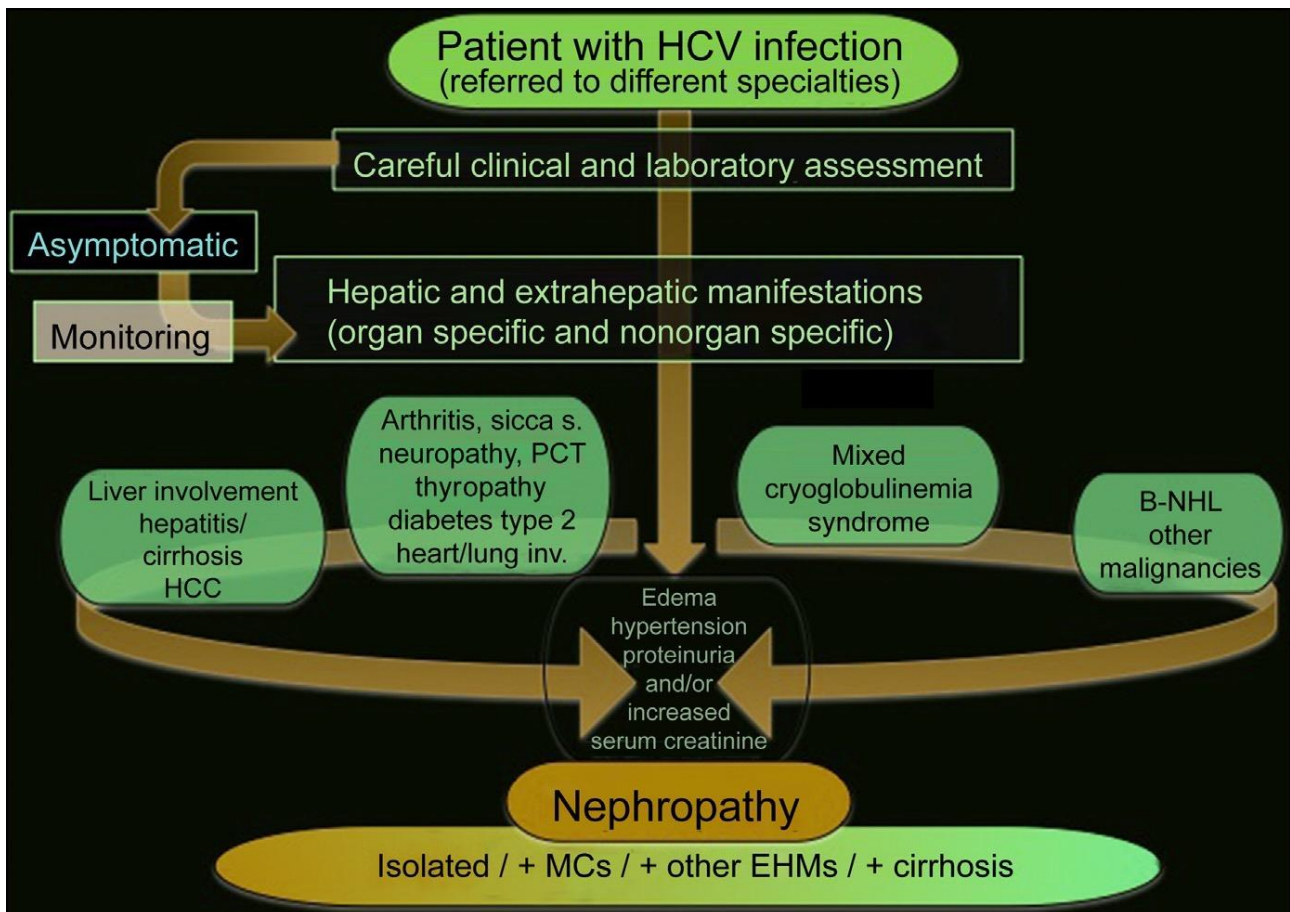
HCV-related nephropathy: clinical assessment and diagnosis. Patients with HCV infection should be systematically investigated with regards to both hepatic and extrahepatic autoimmune/lymphoproliferative and neoplastic disorders, regardless of the specialty of the referral centers. In addition, asymptomatic HCV-infected subjects should be monitored to detect possible hepatic and HCV-EHMs early, including urinalysis and sediment evaluation. Nephropathy may be easily suspected in the presence of urinary abnormalities, edema, hypertension, proteinuria and/or increased serum creatinine, ultrasound kidney evaluation, and if opportune renal needle-biopsy. Clinically, renal manifestations, mainly the MPGN, can be observed as isolated manifestation or more frequently in association with MCS or other HCV-EHMs; alternatively, it may complicate severe hepatic (decompensated cirrhosis), metabolic (diabetes), and/or cardiopulmonary manifestations. inv, involvement; HCC, hepatocellular carcinoma; MCs, mixed cryoglobulinemia syndrome; NHL, non-Hodgkin lymphoma; PCT, porphyria cutanea tarda; s, syndrome.
